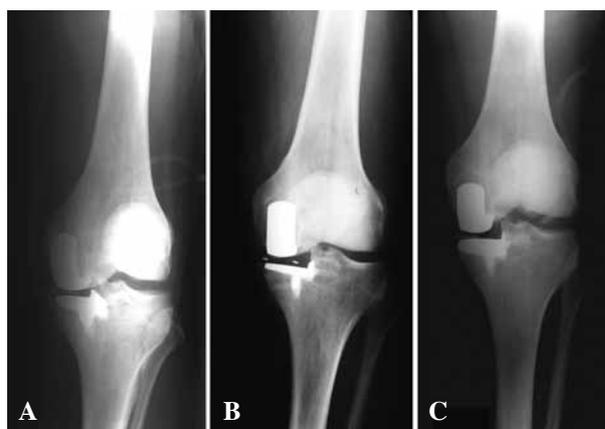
Radiographs of a left Oxford II UKA. A: Postoperative anteroposterior (AP) view, B: AP view showing a meniscal bearing (size 1) dislocation at 2 weeks postoperative, C: Post revision AP view showing a correct position of the inlay (size 4).
